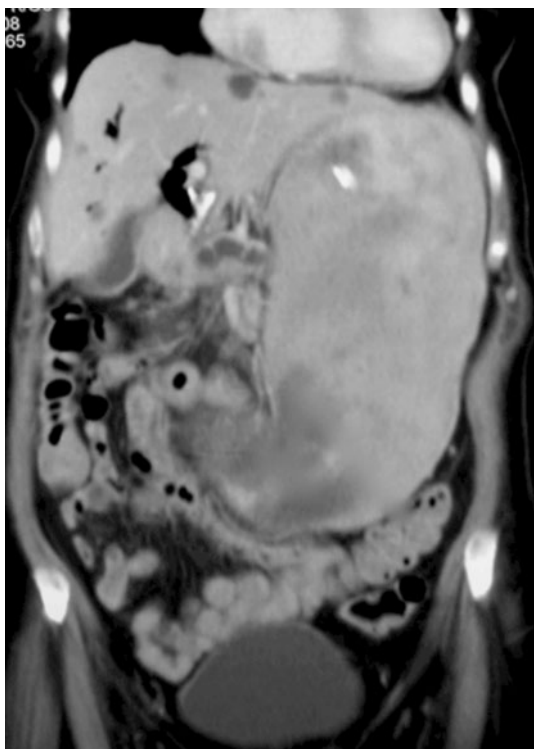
Computed tomography (CT) scan showing a grossly dilated stomach in a patient with gastric outlet obstruction from metastatic pancreatic cancer. Liver metastatic deposits can be seen, as well as gas within the biliary resulting from of the biliary stent
